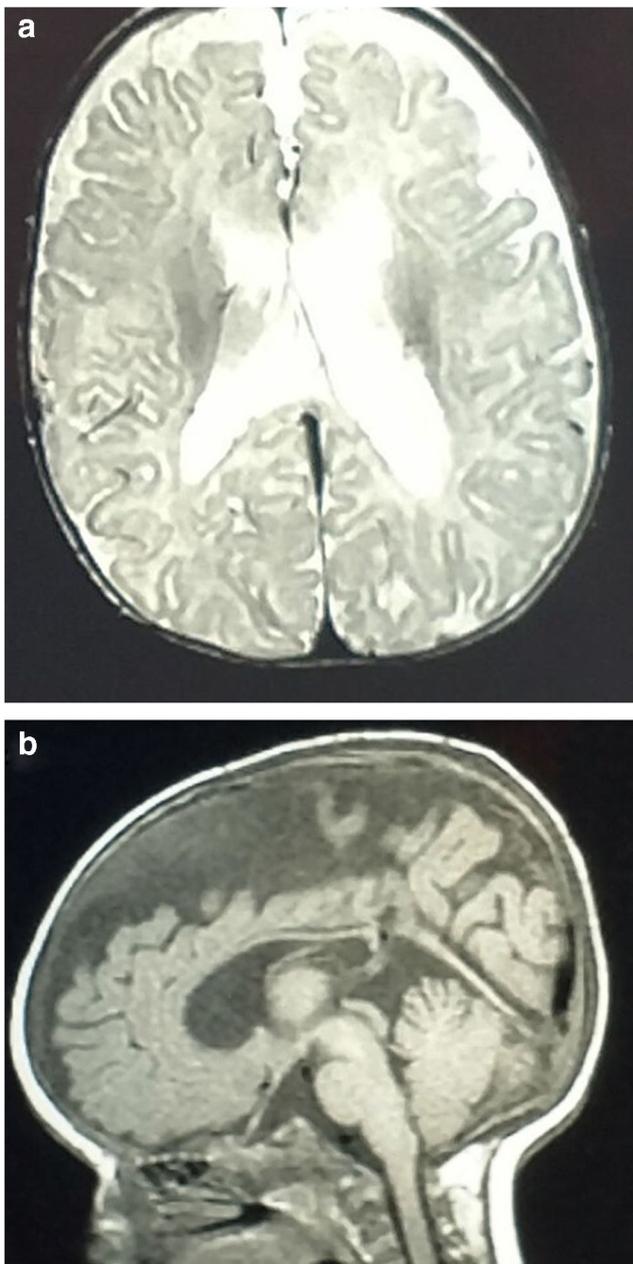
a Axial T2 MRI image from MRI prior to the first shunt surgery showing both increase in ventricular size and increase in CSF in the cortical subarachnoid space. b Sagittal T1 image preoperatively also showing markedly increased subarachnoid CSF
